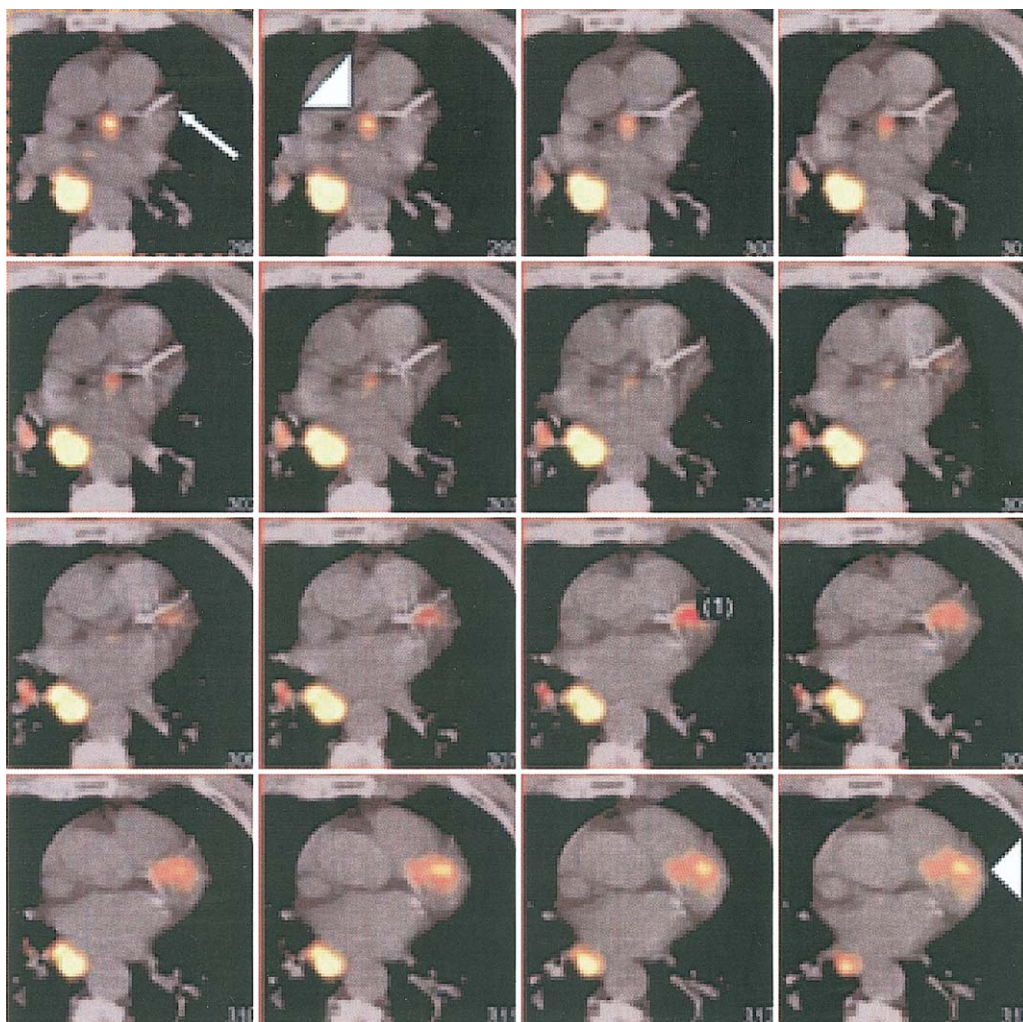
Images from combined positron emission tomography (PET)/computed tomography (CT) scanner showing coronary fluorine-18-labeled deoxyglucose (FDG) uptake. Fused PET/CT images show contiguous transaxial slices through heart. Inflammation (arrowheads) is present proximal and distal to the calcified left anterior descending artery (arrow). A tumor sits adjacent to esophagus. Reprinted, with permission, from Dunphy *et al.* (43).
